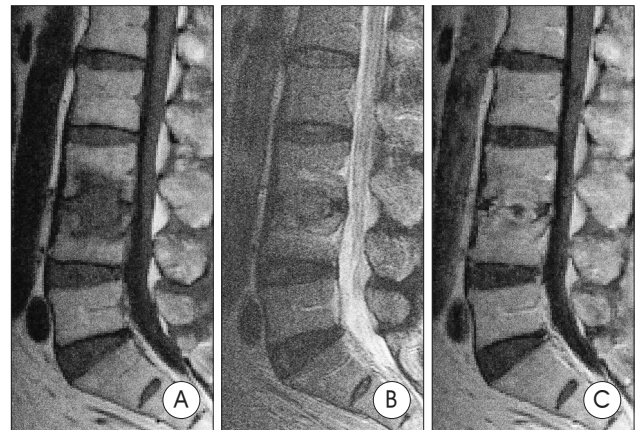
The magnetic resonance(MR) images of patient No. 1 at stage C after complete treatment. Four months after intravenous antibiotic treatments, the low signal intensity on T1 WI (A) and the high signal intensity on T2 WI (B) are reduced and stabilized. The gadolinium-enhanced MR images (C) are also enhanced especially in the involved disc space.
